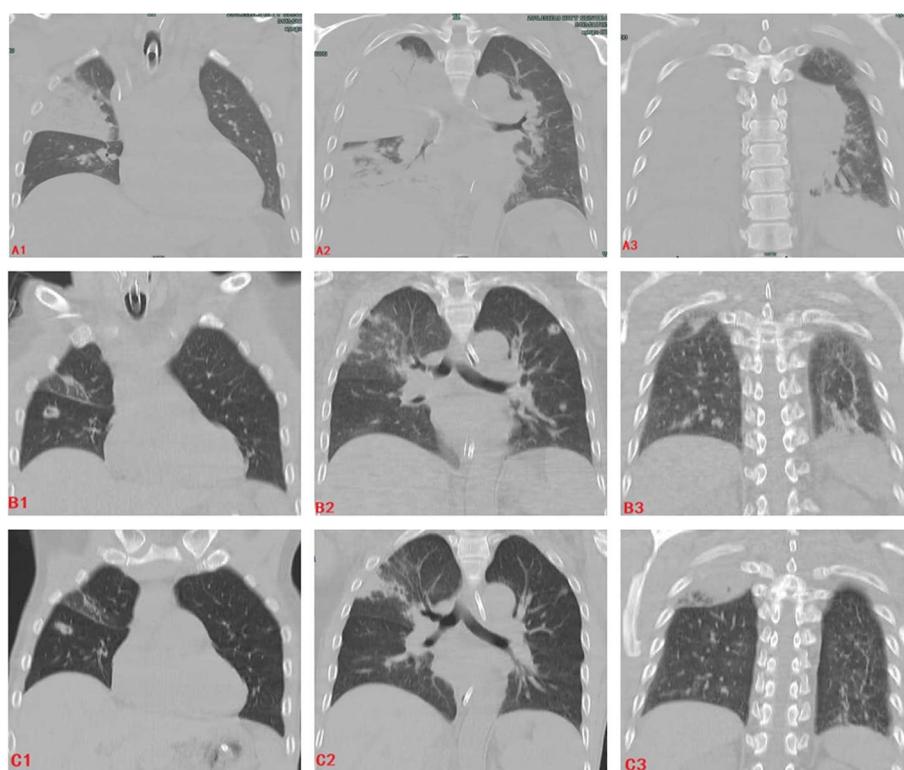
a Chest CT on admission revealed obvious consolidation of the right lung b Chest CT examination on 17 days after admission revealed multiple nodular high-density shadows in both lungs with cavity formation c Chest CT examination on 35 days after admission revealed multiple solid nodules in both lungs with cavitation
